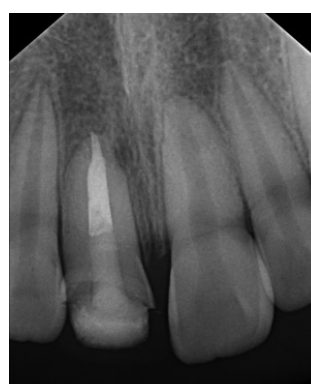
Periapical view after 8 weeks of stabilization, showing good bony repair.
